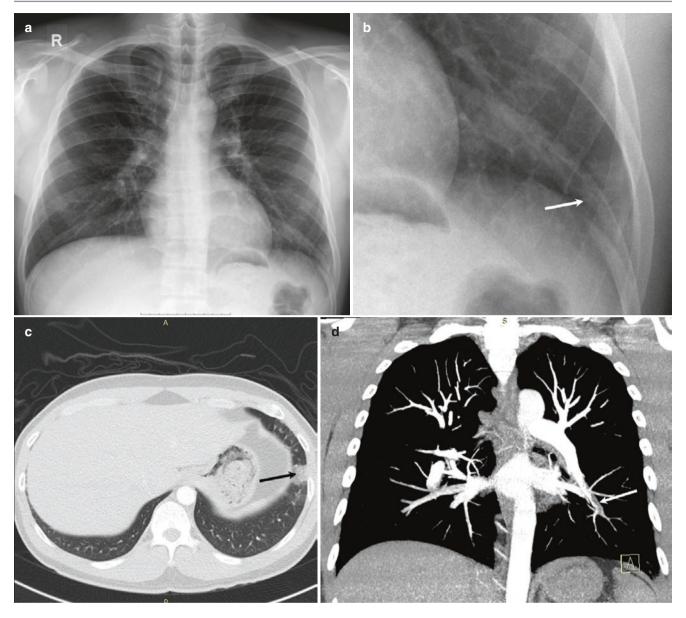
A 27-year-old man with PE presented to the emergency department with chest pain and dyspnea. (a) Frontal radiograph shows a subtle peripheral wedge-shaped opacity (Hampton hump) in the left lower zone.
